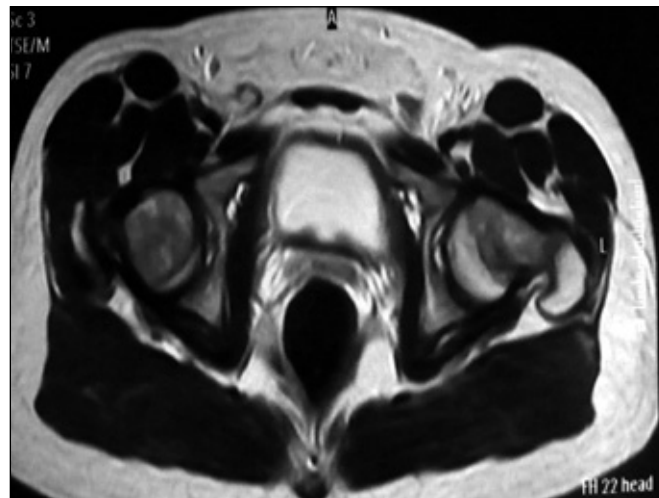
MRI-slice of both hips showing the slip (case no. 4) shows the callus at the posterior head neck junction.
